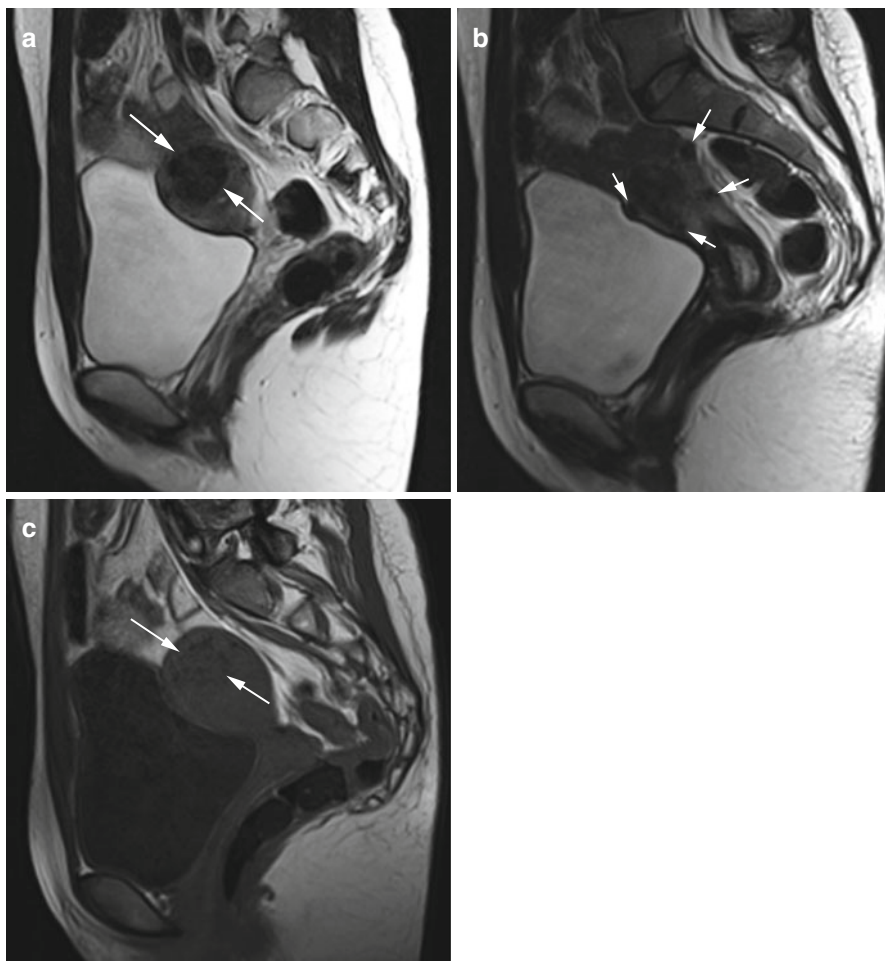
(a) Sagittal T2w image reveals a well-defined, homogeneous mass of low signal intensity in the uterine myometrium (*arrows*) in a 27-year-old subject. (b) Sagittal T2w image demonstrates additional rounded masses, which are subserosal in location (*arrows*). (c) Sagittal T2w image again shows the large intramural mass, which is slightly hypointense (*arrows*). In summary, MRI shows a myomatous uterus with a large intramural fibroid and multiple subserosal fibroids
